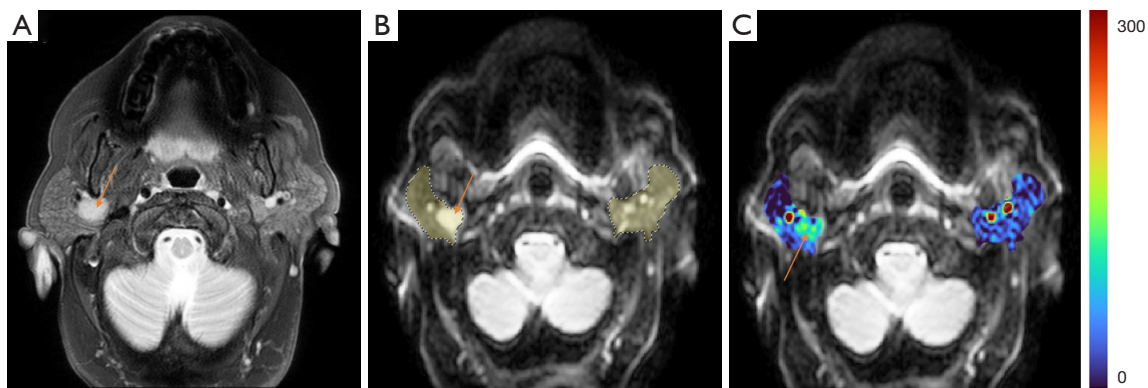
A case of right parotid gland malignant tumor (arrow) with bilateral parotid gland segmented and overlaid on $b=0$ s/mm^2 DW image. DDVD map is computed from $b=0$ and $b=20$ s/mm^2 images. Tumor appears higher perfusion relative to adjacent parotid gland tissue. Note that vessels near the parotid gland show very high signal on DDVD map. (A) T2-weighted anatomical image; (B) $b=0$ s/mm^2 DW image with bilateral parotid glands and tumor segmented by ROIs (dashed circles); (C) DDVD maps of bilateral parotid glands and tumor are overlaid on $b=0$ s/mm^2 DW image. DDVD, diffusion-derived vessel density; DW, diffusion weighted; ROI, region-of-interest.
